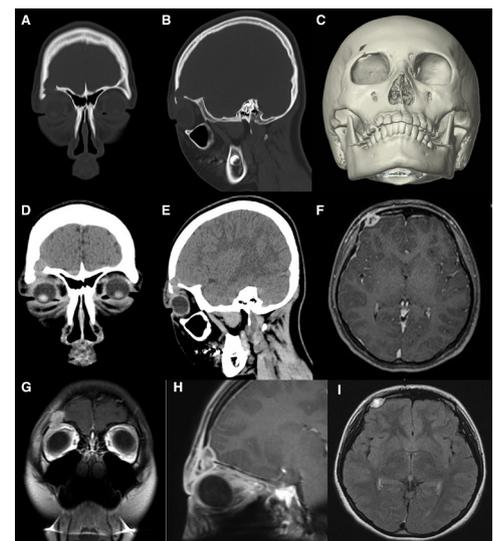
(A–C) Bone CT scans on admission showing an osteolytic lesion in the right frontal and zygomatic bones. (D, E) Head CT scans on admission. (F–H) Contrast-enhanced T1-weighted MRIs on admission showing a heterogeneously contrast-enhanced mass extending from the intraorbital space to the subcutaneous space. (I) Fluid-attenuated inversion recovery image on admission.
